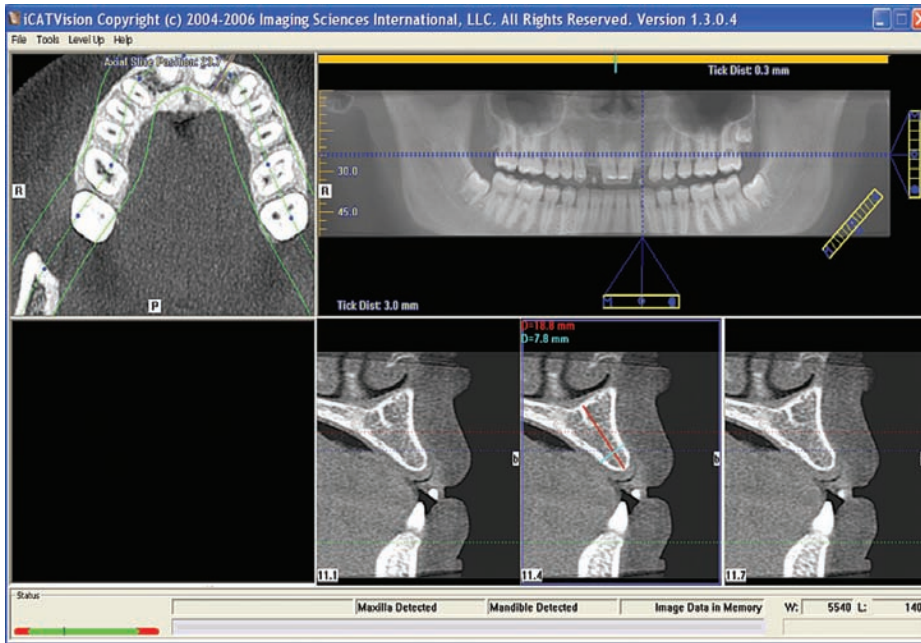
An i-CATVision (Imaging Sciences, Hatfield, Pennsylvania, U.S.) scan using cone-beam technology that leads to a reduction in radiation exposure. The images are 1:1 allowing distances to be measured on the cross-sectional images (*bottom right*). The panoramic view generated (*top right*) is free of superimposition of adjacent anatomical tissues. Manipulation of the “focal trough” on the axial view (*top left*) can be carried out to yield an accurate view.
